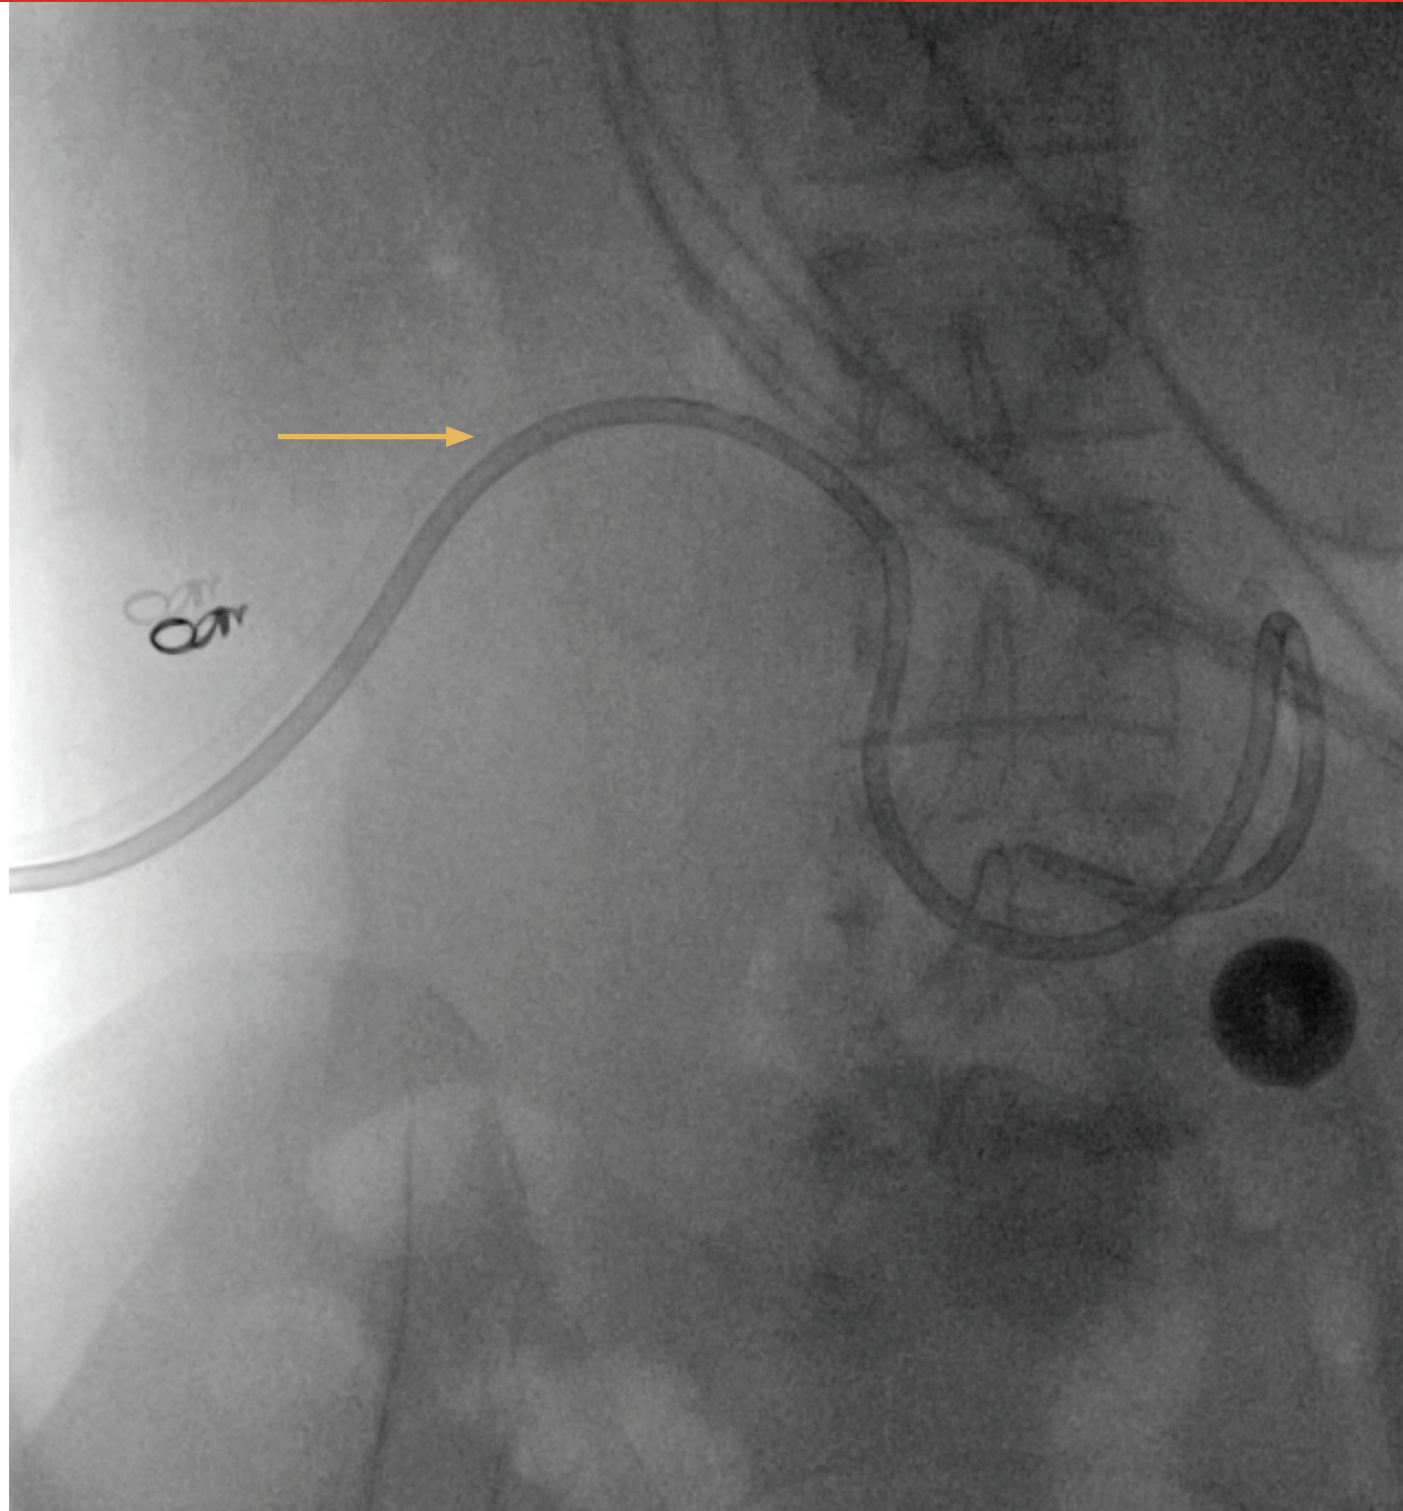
X-ray scout image showing internal-external biliary drainage catheter (gold arrow).
